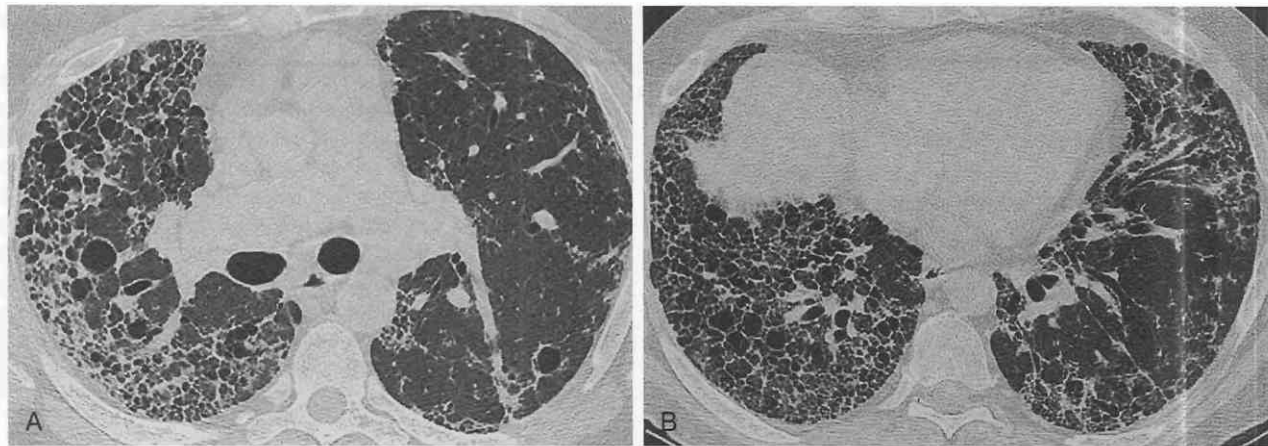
A and B, Interstitial pulmonary fibrosis associated with polymyositis. High-resolution CT shows reticulation and honeycombing in the periphery of the lung and in the lung bases, more severe on the right than on the left. Note "traction" bronchiectasis due to interstitial fibrosis.
